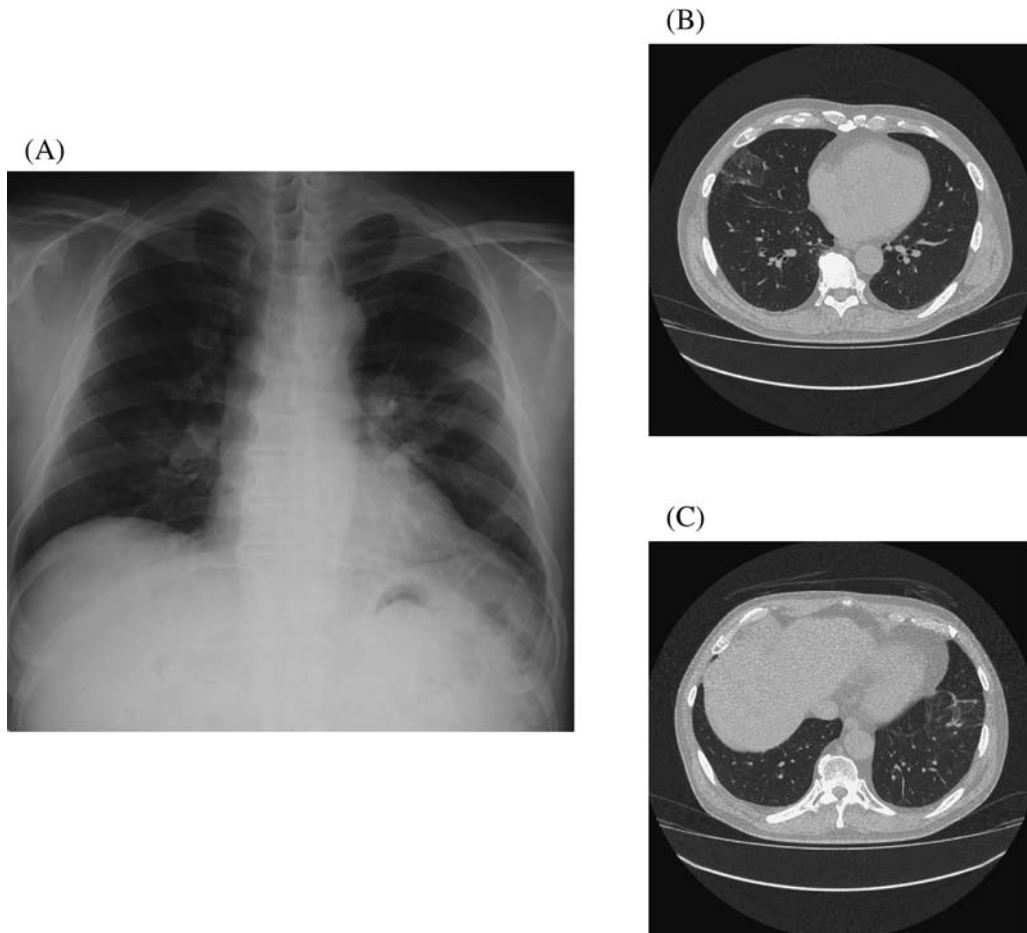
Chest X-ray films on admission. (A) Chest X-ray film showing infiltrative shadow in both middle and lower lung fields. (B) and (C) CT scan images showing consolidation with ground-glass opacity at right upper lobe and left lower lobe.
